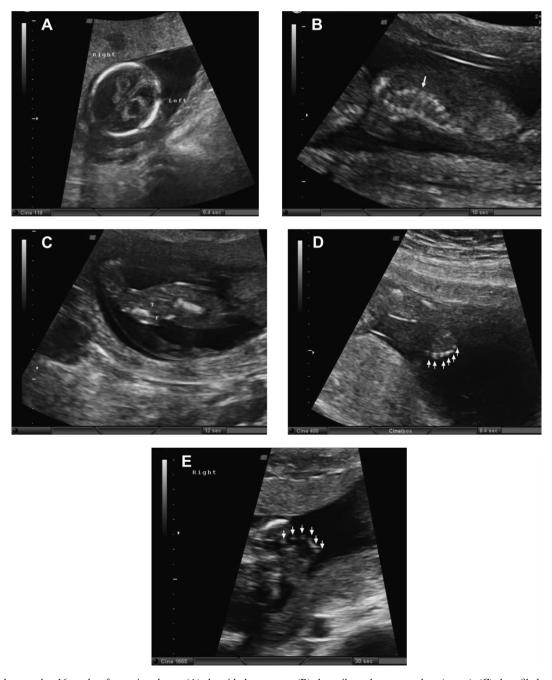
Prenatal ultrasound at 16 weeks of gestation shows: (A) choroid plexus cysts; (B) short ribs and a narrow chest (arrow); (C) short fibula and tibial aplasia; and (D) and (E) polydactyly. F = fibula; T = tibia.
